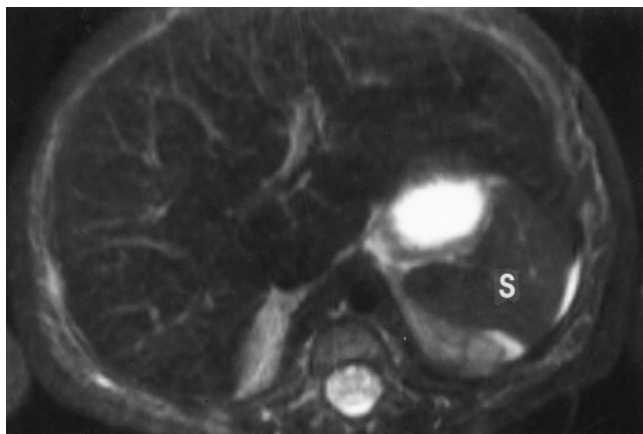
Normal spleen in a 1-month-old patient. T2-weighted fat-suppressed spin-echo image. Normal spleen (S) is low signal intensity, comparable to liver on T2-weighted image.
